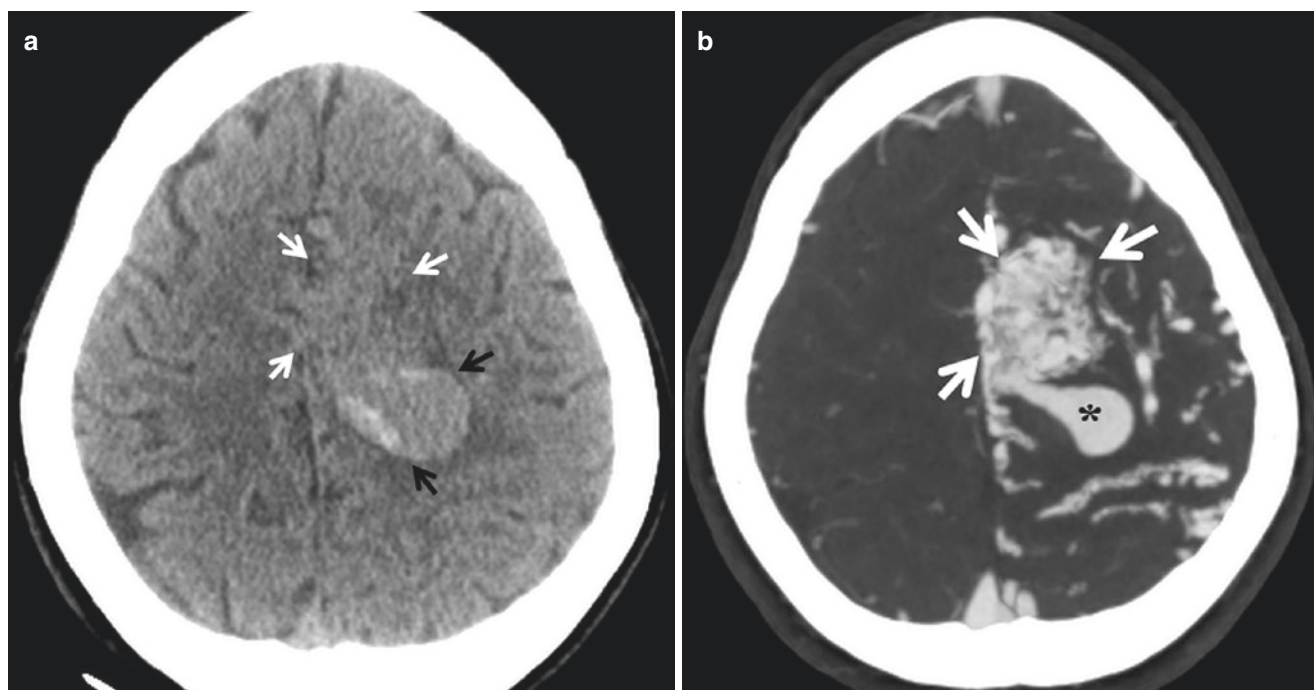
Unruptured AVM. A 19-year-old presents with headache and weakness. (a) NCCT shows a mixed density oval structure (black arrow) in the deep posterior left frontal lobe. Note serpiginous structures anteriorly (white arrows), suspicious for an underlying vascular malformation. (b) CT angiography demonstrates an AVM nidus (arrow). The contrast-filled sac posteriorly (*) represents a large nidal aneurysm, corresponding to the oval structure seen on the NCCT. (c) 3D reconstructed CTA with bone subtraction demonstrates hypertrophied arterial feeders from ACA (arrow) and MCA (curved arrow). (d) AP view from catheter angiogram in early arterial phase demonstrates a
